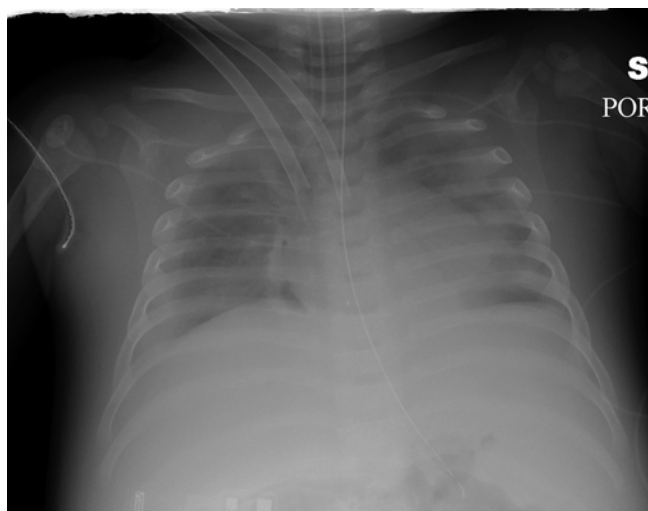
Chest radiograph of patient supported with venoarterial ECMO demonstrating usual position of tips of venous drainage cannula (white dot) and arterial cannula
